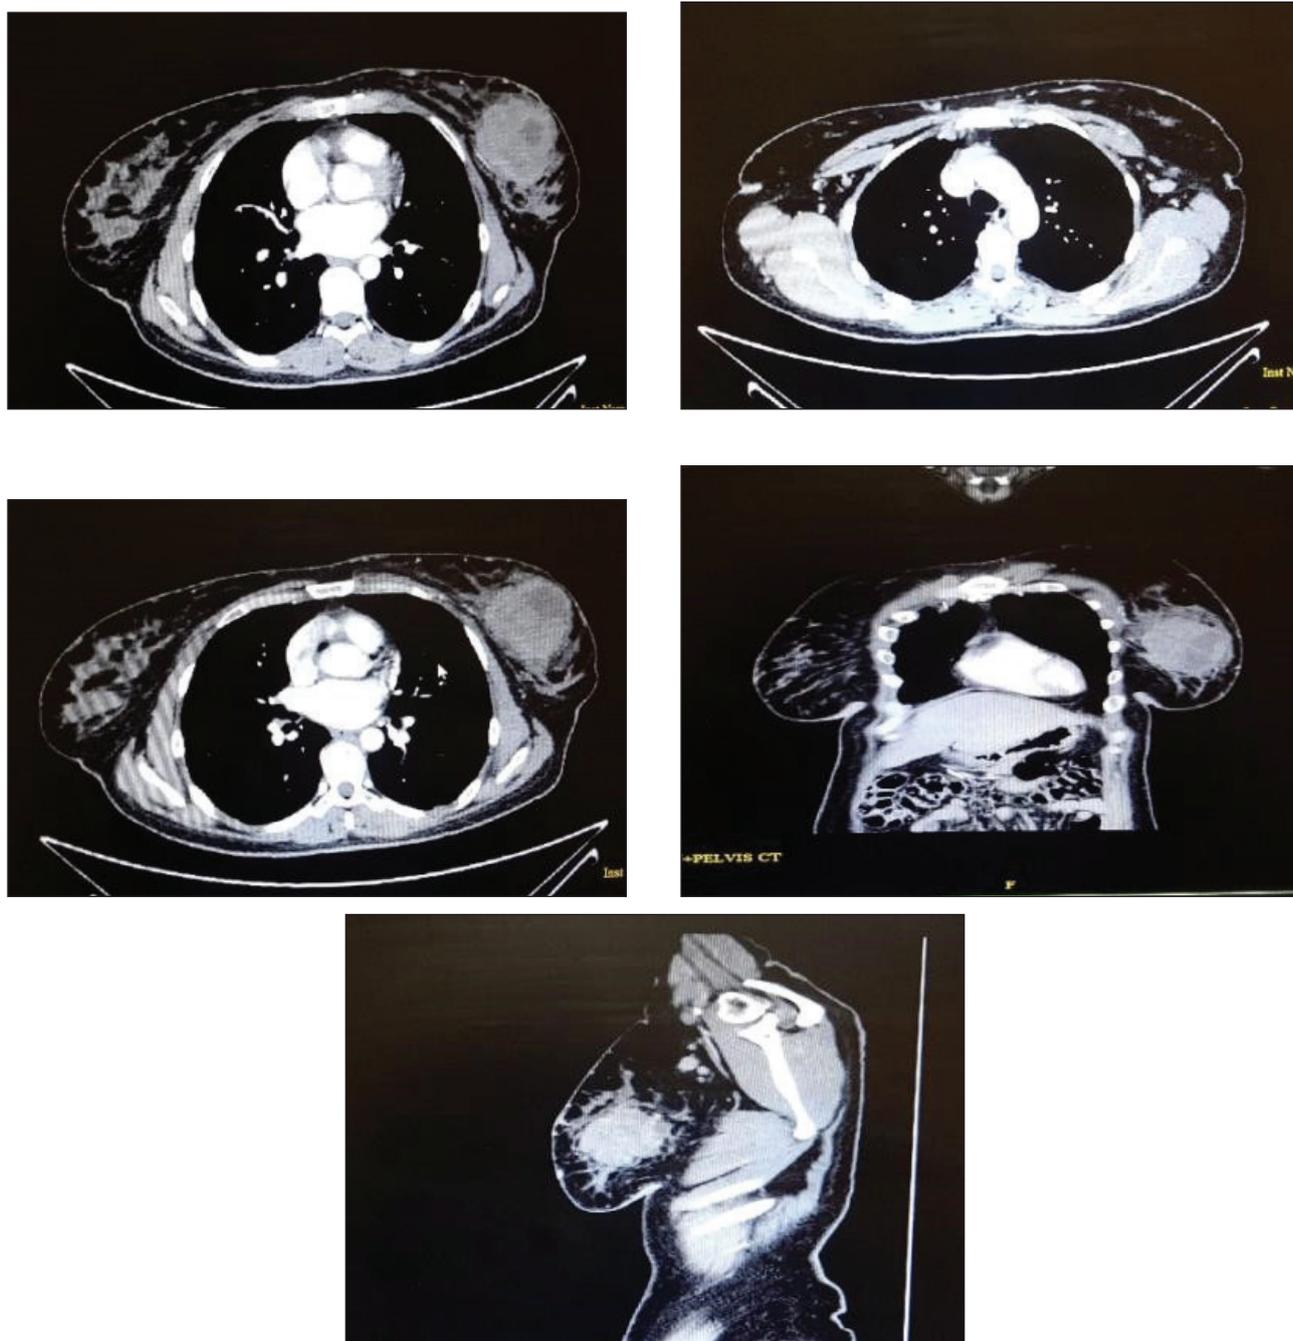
CT scan of breast as part of the staging CT: (a., b., c.: transverse planes.) (d: Coronal plane.) (e: Sagittal plane).
